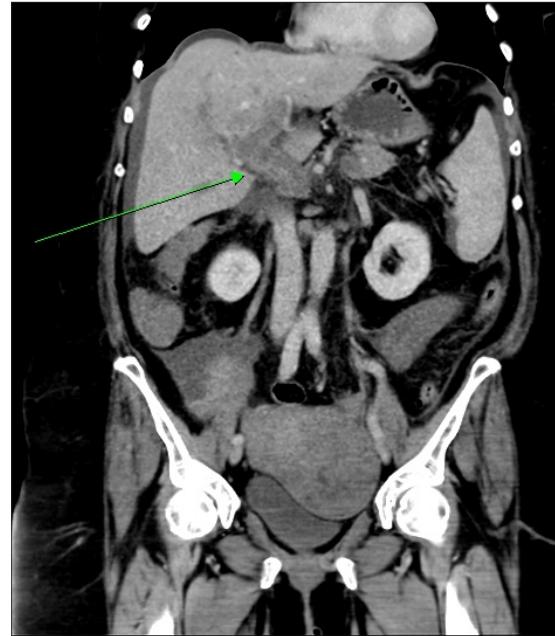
CT images - Thrombosis of main portal vein (White arrow) with coincidental benign uterine lesion.
